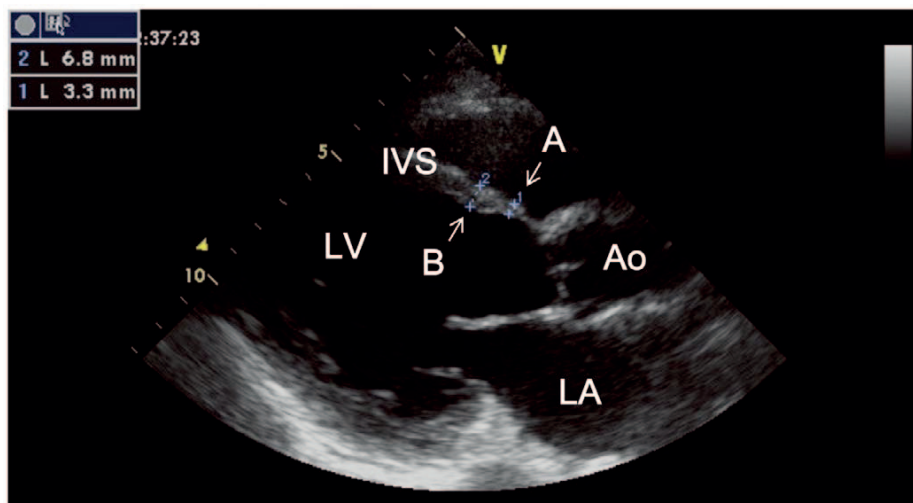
Echocardiographic image of CS with basal thinning. IVS=interventricular septum, A= point located 10mm from the aortic annulus, i.e. basal IVS, B= IVS at the standard level of the mitral valve leaflet tips, Ao=aorta, LA=left atrium, LV=left ventricle. Adapted from (184).
